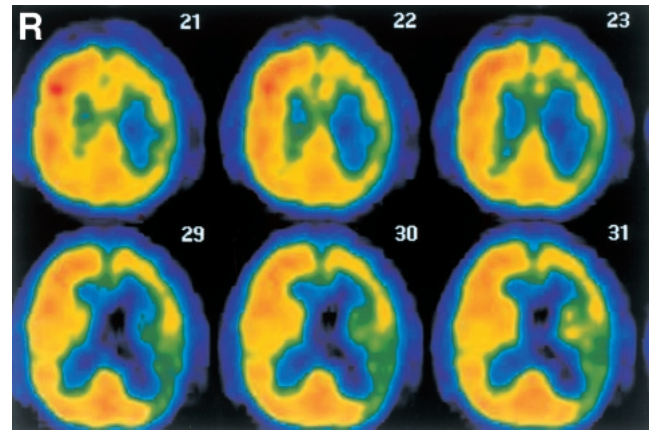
Brain technetium-99m exametazime single photon emission computed tomography scans revealing a region of decreased perfusion in the left frontoparietal cortex.
